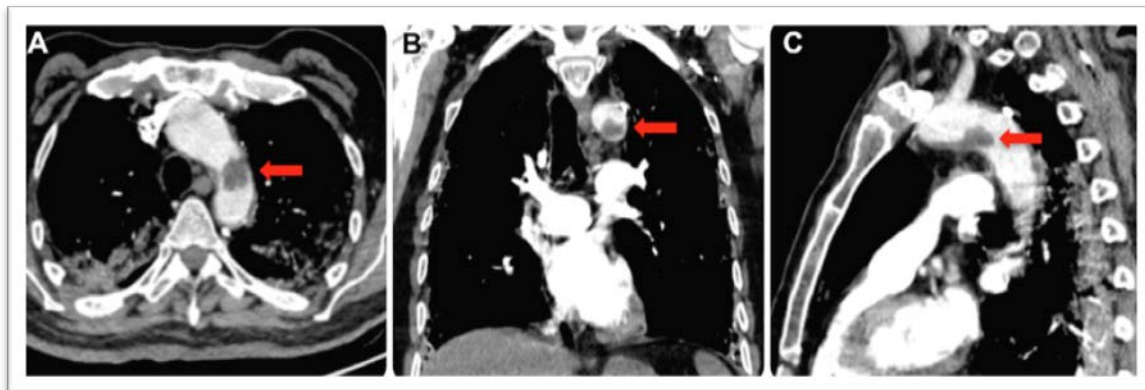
Computed tomographic pulmonary angiography (CTPA) shows an acute mural thrombus in the aortic arch
